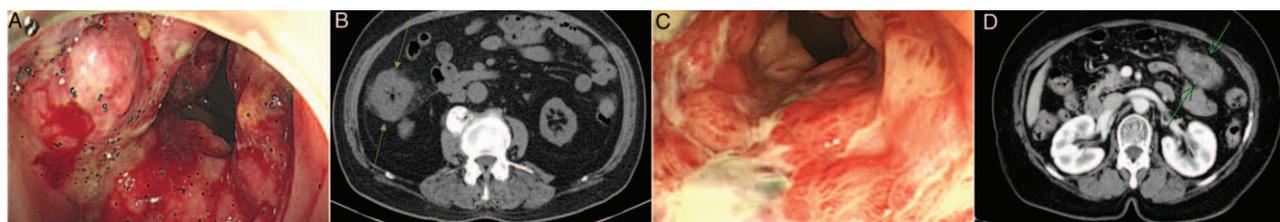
(A) The colonoscopy showed an ulceroinfiltrative mass-like lesion in the ascending colon (case 1). (B) Computed tomography imaging showed segmental wall-thickening of the proximal ascending colon with pericolic infiltration (case 1). (C) Colonoscopy revealed a 4-cm ulceroinfiltrative mass in the splenic flexure (case 2). (D) CT imaging revealed diffuse wall-thickening with serosal infiltration (case 2).
